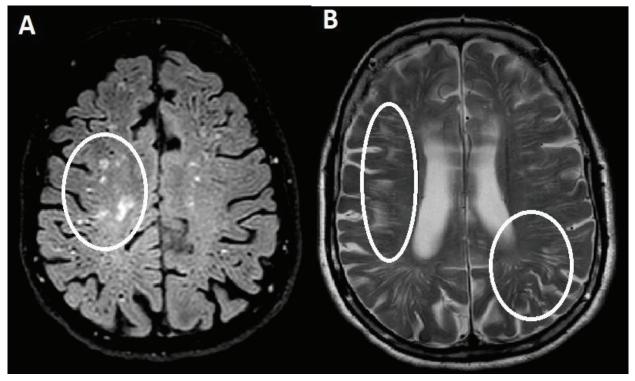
Showing multiple areas of hyperintensity in the subcortical areas on A-FLAIR sequences and B-T2 sequences representing ischaemic changes
